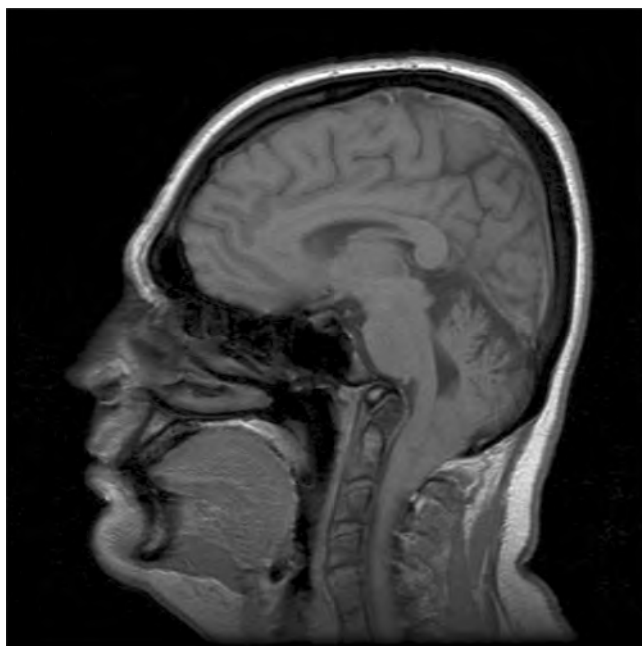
Chiari I malformation. MRI showing pre-operative appearances.
